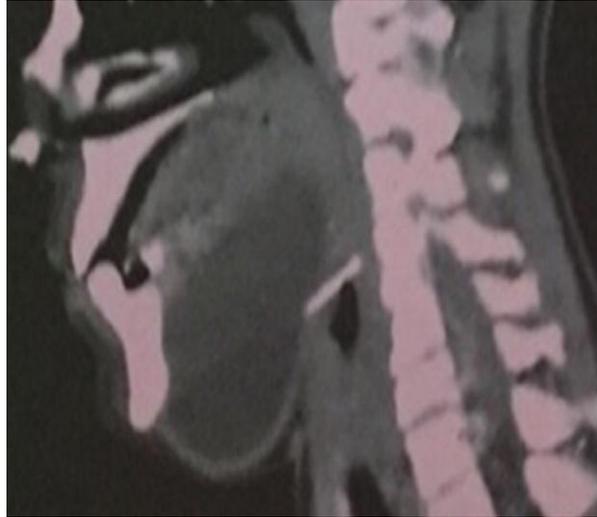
CT scan showing Ranula.
